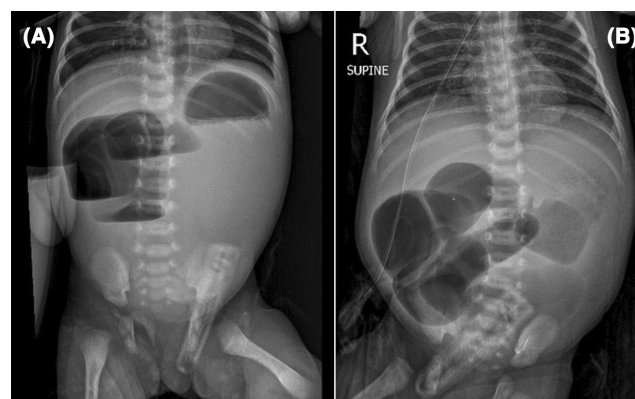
(A) Erect abdominal x-ray showing multiple air-fluid levels. (B) Supine x-ray showing “double-bubble” sign.
